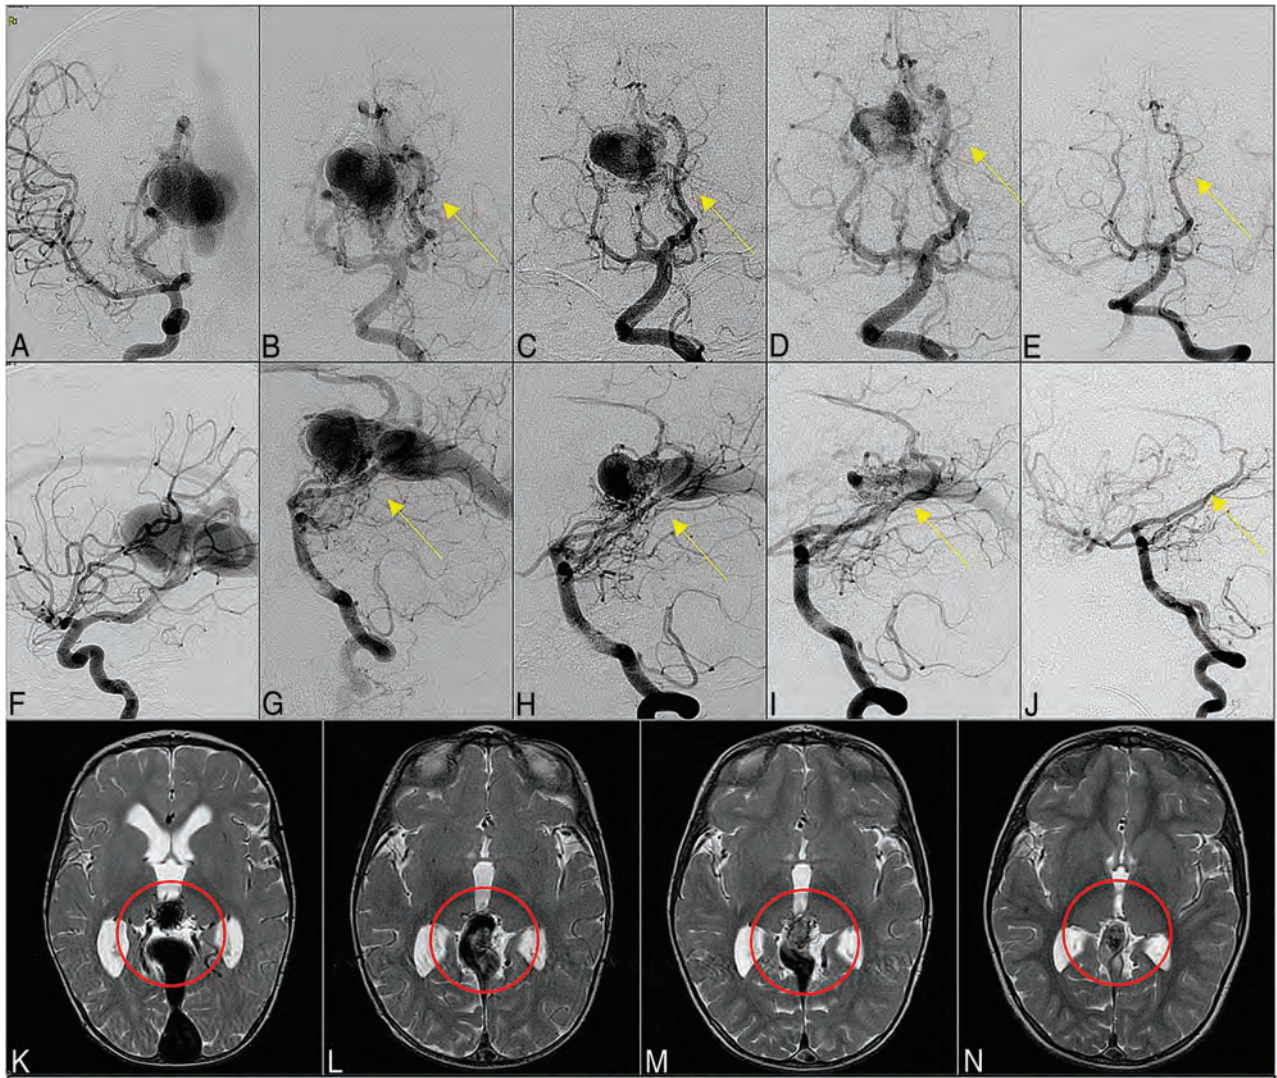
Angiogram. Anterior-posterior (A–E) and lateral (F–J) views of the angiogram and T2-weighted MR imaging (K–N) of case 23. We show a progressive diminution of the FVNF bilaterally at the thalamus with a bias for the right side (B–E, G–J, K–M) observed after initial treatment (A and F). This reduction was achieved through staged embolization of feeder vessels to the VGAM staged from 0.5 to 3 to 20 to 72 months.
